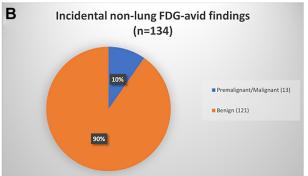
FIGURE Pie charts depicting that (A) 80% of patients with pathologic lymph node–positive (pN+) disease were missed by fluorodeoxyglucose (FDG) positron emission tomography (PET) and (B) >90% of patients with incidentally detected FDG-avid distant lesions had benign disease.
